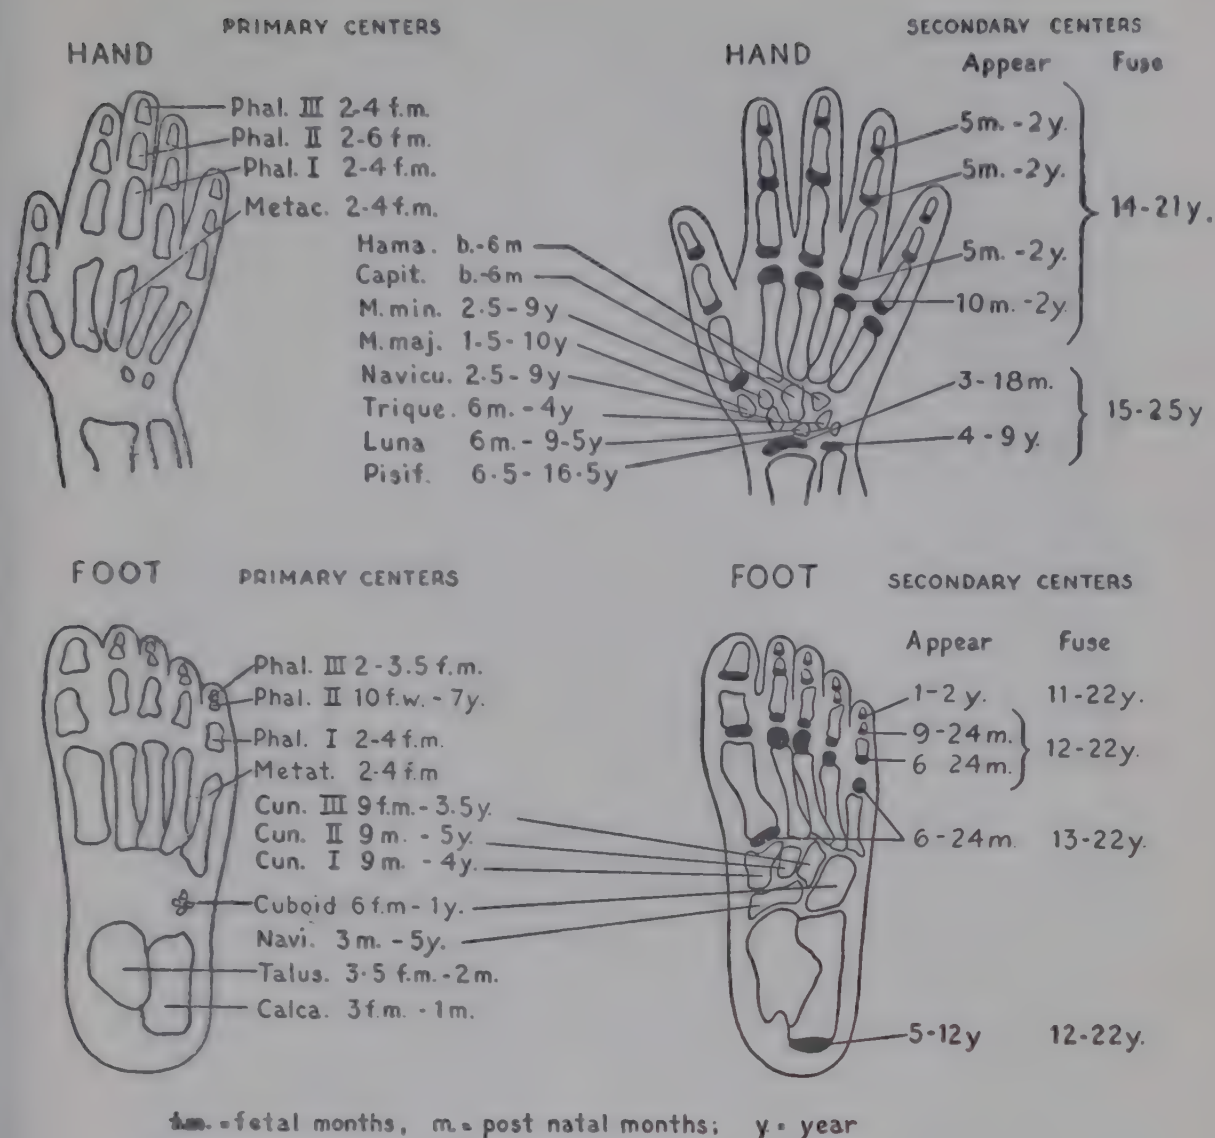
Ossification centers of the hands and feet, showing time of appearance. Note the wide range of "normal" and compare with Table 23. (From Caffey, J.: *Pediatric X-Ray Diagnosis* [2d ed.; Chicago: Year Book Publishers, Inc., 1950]; modified from Scammon in *Morris' Human Anatomy*.)
